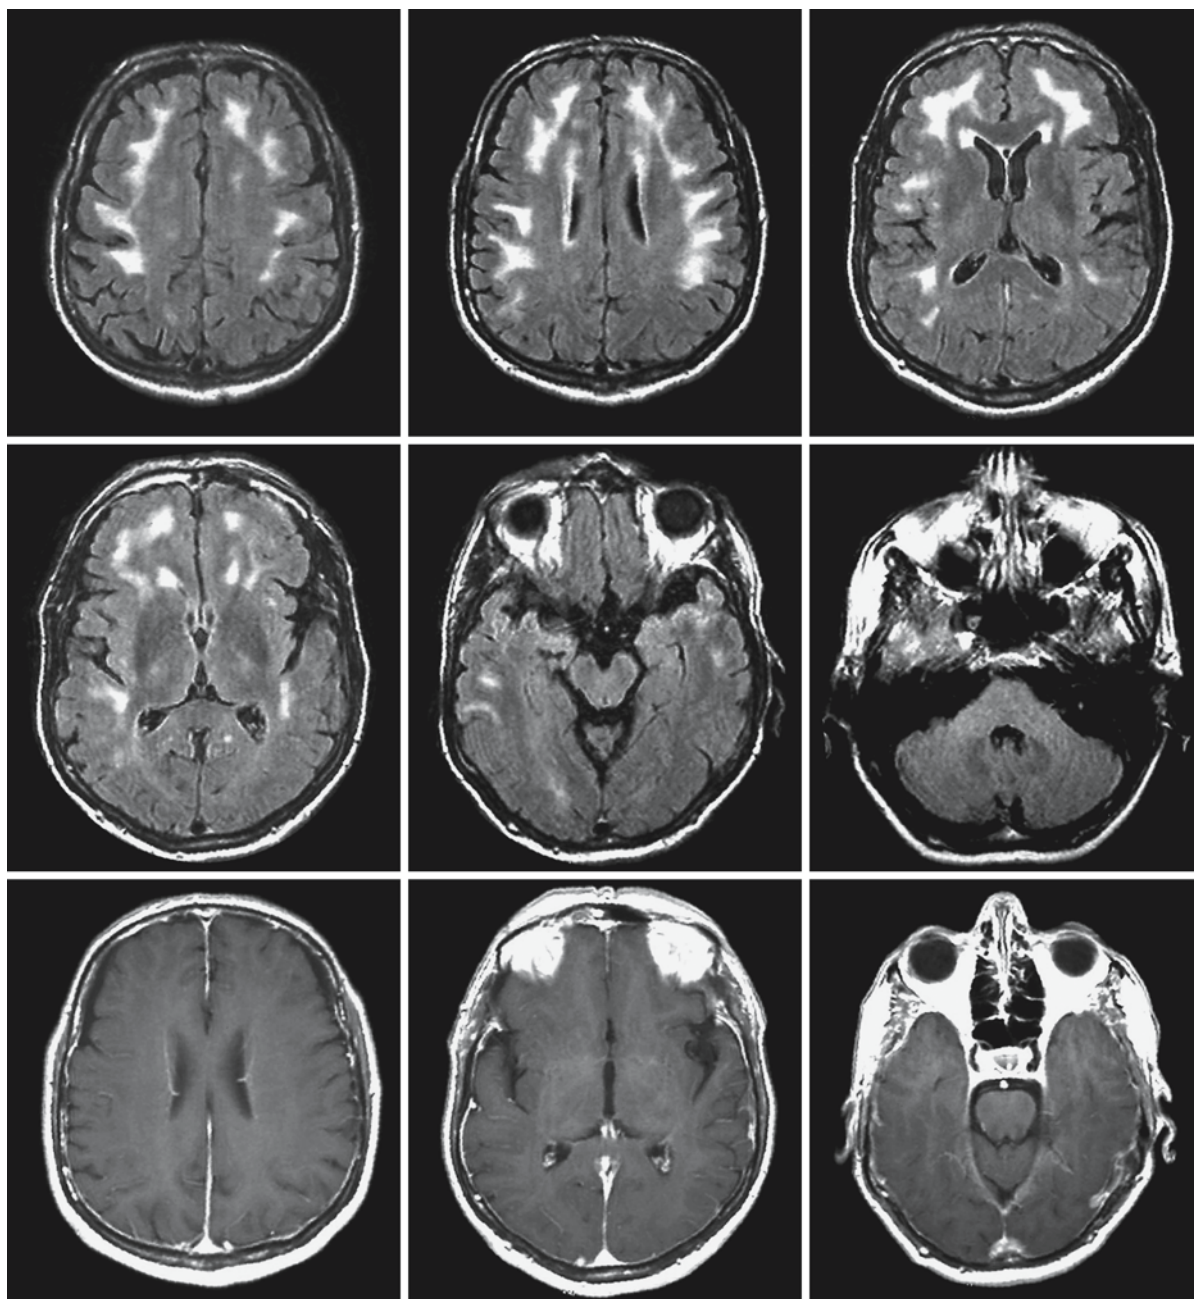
Brucellosis in a 70-year-old man. The FLAIR images (*first and second rows*) show frontoparietal involvement of the arcuate fibers and a hyperintense rim around the ventricles.
